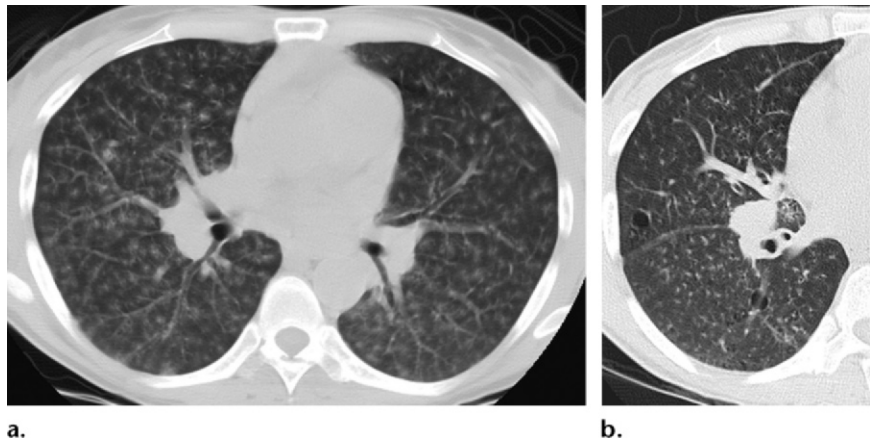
LIP in a 35-year-old woman who presented with fever, dyspnea, and cough. The patient's CD4 count was 328 cells/ μ L, and a diagnosis of HIV infection was made. (a) CT image shows diffuse, ill-defined centrilobular nodules, which did not respond to antibiotic treatment. ART was initiated, but similar symptoms and radiographic abnormalities persisted for over 10 years. Bronchoalveolar lavage revealed 78% lymphocytes with a decreased CD4-CD8 ratio. Transbronchial biopsy was nondiagnostic. (b) CT image obtained 10 years after the initial examination (cf a) shows lung cysts. A presumptive diagnosis of LIP was made based on the combination of clinical, laboratory, and radiologic findings.
